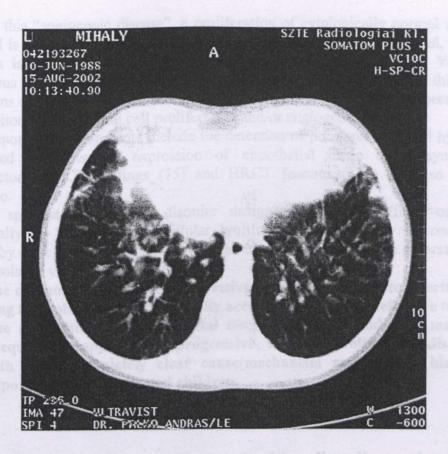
CT-scan (see text)
